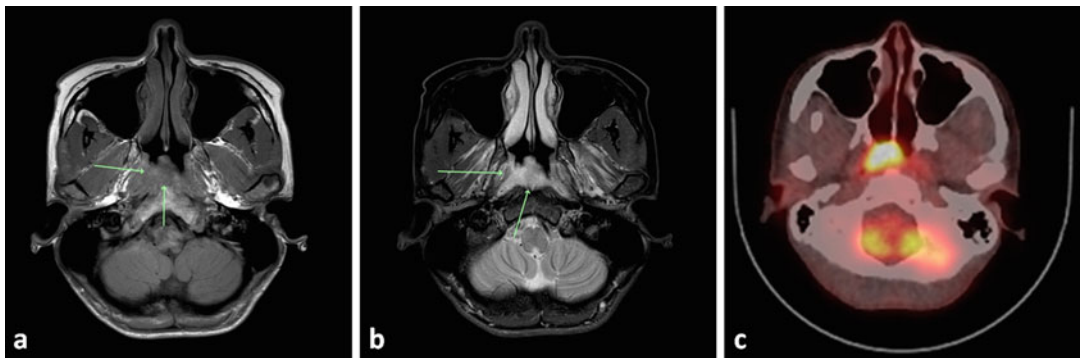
T1N2M0 nasopharyngeal carcinoma. On MRI there is a polypoid carcinoma in the right central aspect of the nasopharyngeal mucosal space. The tumor demonstrates T1 isointensity (a) and T2 hyperintensity (b) with mild to moderate enhancement. The lesion measures 26 mm transverse \times 9 \times 22 mm AP and 8 mm craniocaudal. There is preservation of the normal marrow signal of the clivus with no evidence of central skull base
